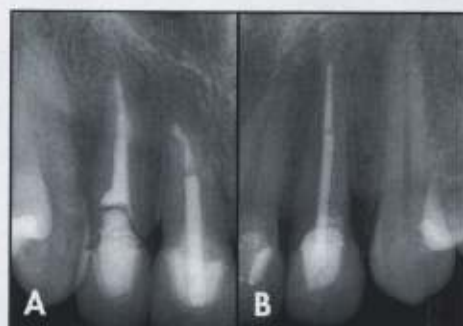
Preoperative radiograph of the right maxillary anterior regions. 2B. Periapical radiograph of the left maxilla.
